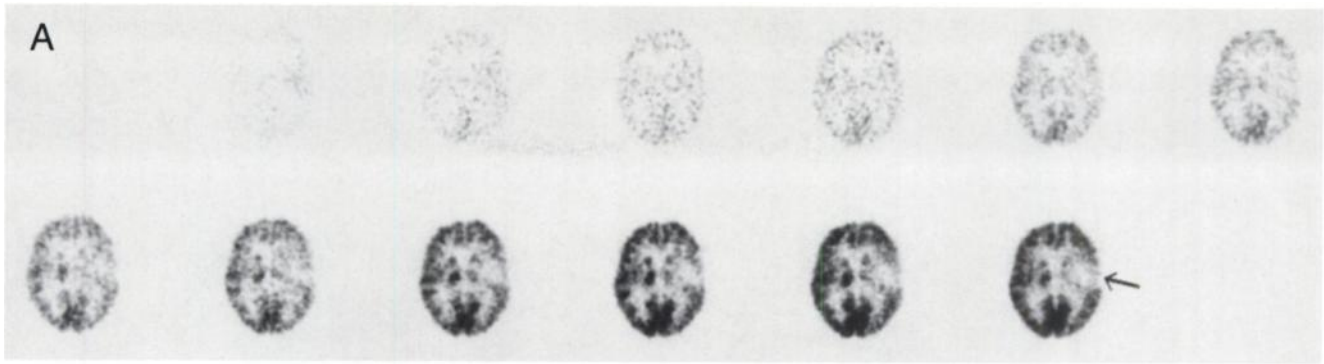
A 13-frame dynamic ^{18}F FDG brain scan in a patient with a large arteriovenous malformation affecting the left parietal cortex (arrowed). (A) Plane 11 for each of the 13 time frames and (B) the time-activity curves for two ROIs, one in the region affected by the malformation (lower curve, circles) and the other in the same region on the contralateral cortex (upper curve, squares). Note the early peak in the lower curve due to the transit of blood through the malformation and the subsequent significantly-reduced cortical metabolism. The metabolism on the contralateral side appears normal.
